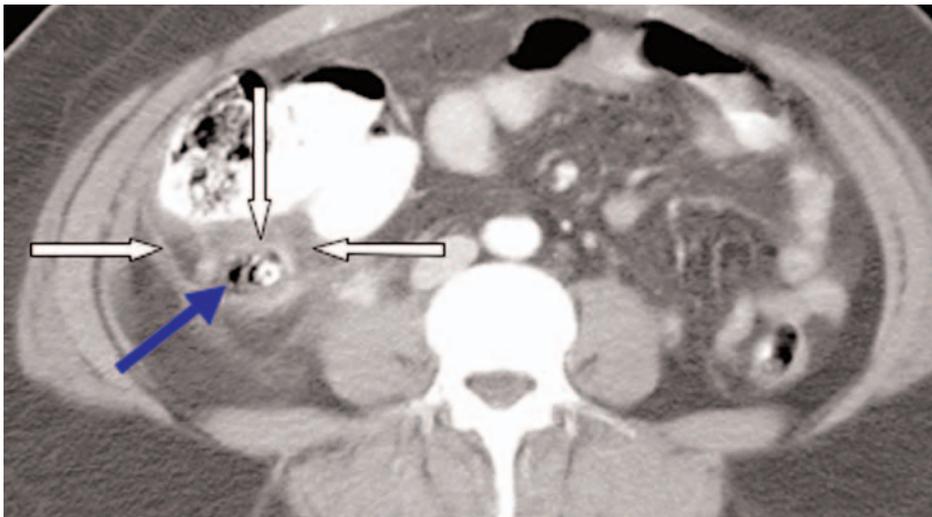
Perforated acute appendicitis on CT. Image exhibits a number of CT findings in acute appendicitis. Periappendiceal inflammation (white arrows) is present in almost all patients with acute appendicitis and is most common finding noted on CT. In this patient, dense appendicolith is noted within appendix. There is gas (blue arrow) adjacent and to right of appendix, indicative of perforation.
